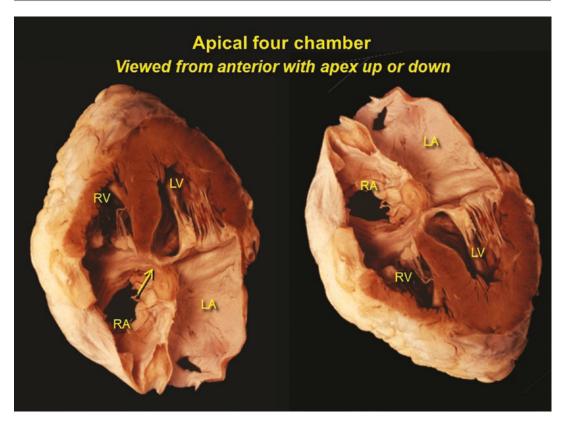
Anatomic cut sections representing the echocardiographic apical four chamber view. The arrow points to the atrio-ventricular septum. Modified from Kisslo, Leech & Adams: Essentials of Echocardiography
